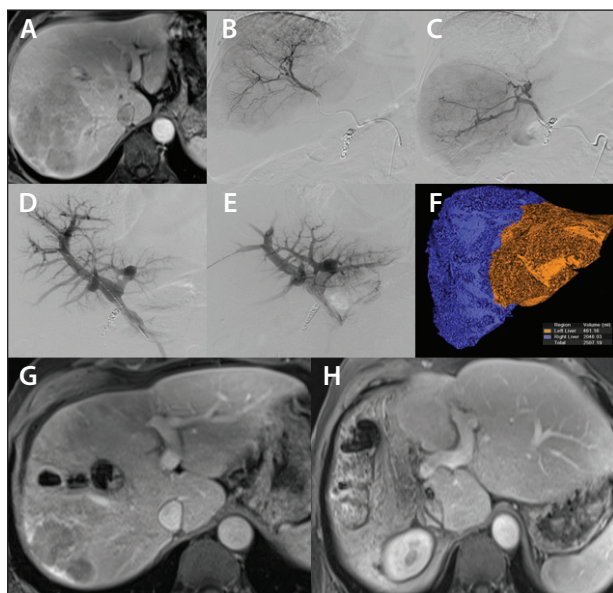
Multifocal HCC within the right liver lobe with small left FLR. Gadolinium-enhanced MRI demonstrating bulky right lobar disease and small FLR (A). Y-90 SIRT of the right liver tumors (bridging therapy) was performed using split doses via the main right hepatic artery (B) and replaced right hepatic artery (C). The patient subsequently underwent PVE following Y-90 SIRT, with transhepatic, transportal venograms depicted pre-PVE (D) and post-PVE (E). Volume-rendered three-dimensional reconstruction with volumes (inset) showing hypertrophy of the FLR (F). Eovist MRI after Y-90 SIRT and PVE demonstrating decreased tumor burden within the right liver lobe and interval hypertrophy of the FLR (note the magnetic artifact from the embolic material placed during PVE) (G). Final image after successful resection of diseased right liver lobe with marked hypertrophy of the left liver remnant (H).
